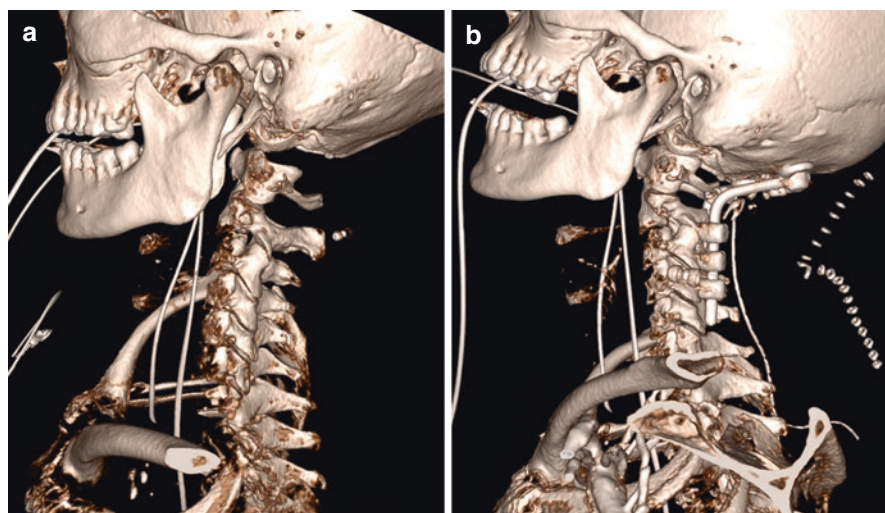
(a) 3-D CT reconstruction of an evident C0–C1 dislocation. (b) Imaging after reduction in halo and surgical C0–C4 fixation
